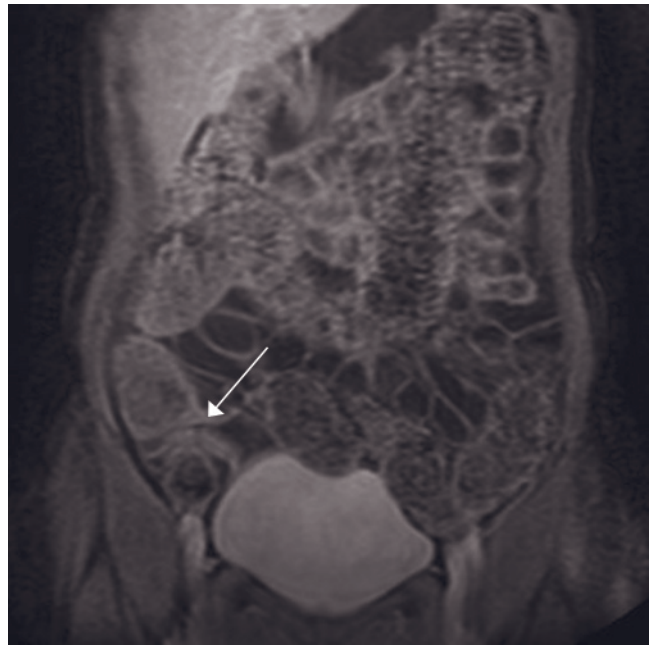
(*Continued*) anti-inflammatory, and oral antibiotic therapy the patient presented with mild pelvic discomfort and pressure symptoms with imaging demonstrating development of a central pelvic abscess situated in the cul de sac on T2-weighted imaging (star, *e*) and delayed gadolinium-enhanced T1-weighted imaging (asterisk, *f*), with a thickened enhancing abscess wall (arrow, *f*). There remains marked diffuse mesenteric edema and fluid (arrow, *e*). Two months after acute presentation, the abscess has been percutaneously drained with complete resolution of the abscess, inflammation, and pelvic edema on T2-weighted imaging (*g*) and gadolinium enhanced T1-weighted imaging (*h*). The TI has returned to nearly the same appearance as 2 years previously
